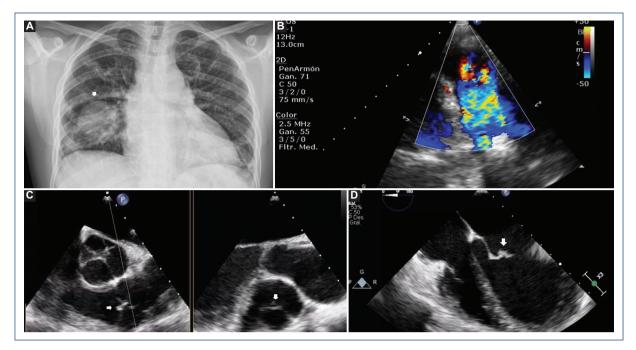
A: postero-anterior chest X-ray projection: significant distal dilatation of right pulmonary artery can be seen (white arrow), along discrete cardiomegaly, CTI 0.52 secondary to left chamber enlargement. B: transthoracic echocardiography, suprasternal view: pulmonary artery trunk is visualized, aliasing is seen due to left to right shunt occurrence, probably due to a patent ductus arteriosus (not appreciated). C: transesophageal echocardiography, upper esophageal view: a hyperechoic image is seen attached to pulmonary valves, corresponding to a vegetation (white arrows). D: transesophageal echocardiography, mid esophageal view: mitral valve is also affected, specifically the anterior valve (white arrows).
